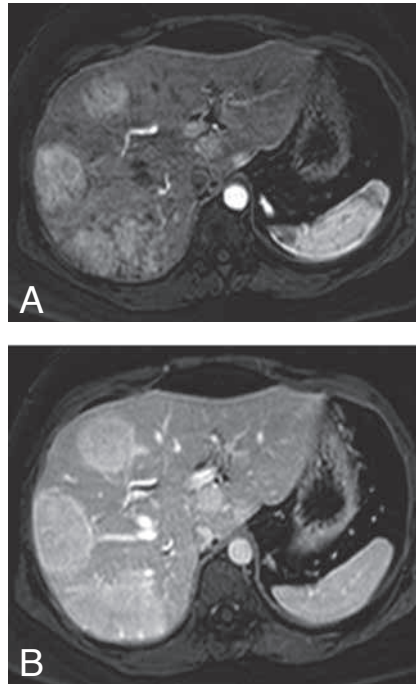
Axial postgadolinium MR images demonstrate the hypervascular nature of all lesions with intense enhancement in the arterial phase (A) persisting in the delayed phase (B).
